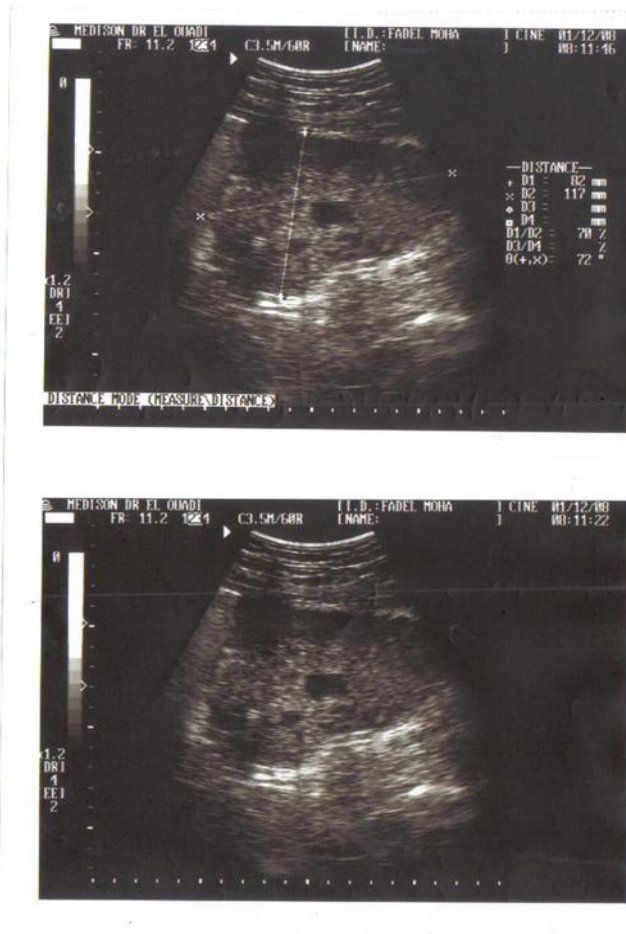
Abdominal ultrasound showing a mass large, multi-lobed, ileal tissue mass
